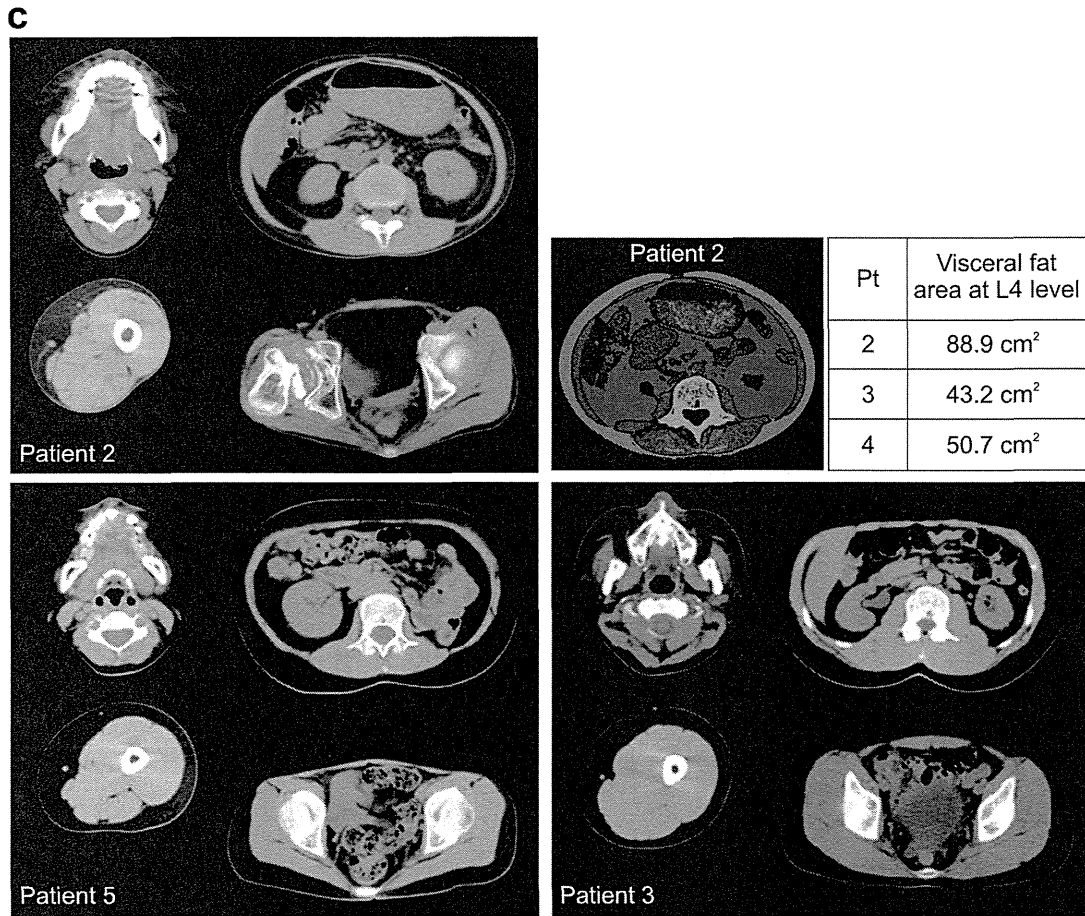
Abnormal fat distribution observed in the patients. a) Facial photos of the patients. Note that the increased subcutaneous fat tissue in the cheeks gives the impression of a moon-face. b) Dual-energy X-ray absorptiometry image of patient 1 (middle) at age 18 yr. Compared with a 25-yr-old obese woman (left), lipoatrophy in the hips and legs and lipohypertrophy in the neck are evident. For comparison, an image of a nonobese, healthy, 29-yr-old woman is also shown (right). Fat content values of various portions of the body are provided under the images. c) Typical whole-body computed tomography scans of patient 2 at age 18 yr, patient 3 at age 19 yr, and patient 5 at age 18 yr. Increased subcutaneous cheek and visceral fat is evident, whereas loss of subcutaneous fat is remarkable in both the buttocks and thighs. In the inset table, the visceral fat area at the 4th lumbar spine level in each patient is provided, along with the image obtained from patient 2.
